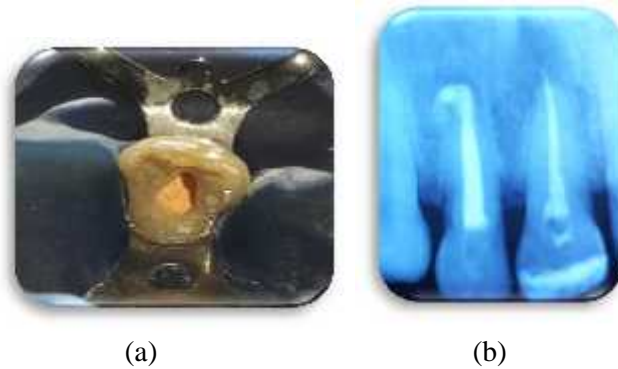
(a) Clinical view after backfill obturation. (b) Periapical radiograph showed placement of apical plug of MTA of 4 mm thickness and obturation of the canal using thermoplasticized gutta percha
